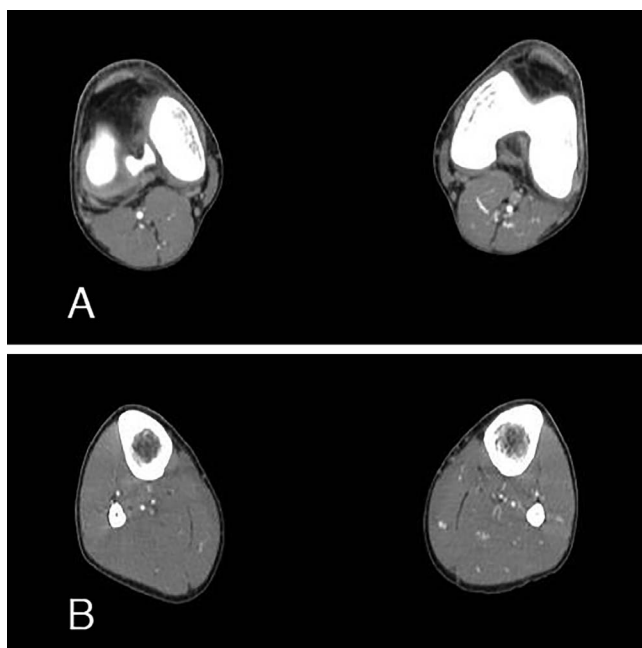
Axial computed tomography angiography images show (A) arterial anatomy at the popliteal that originates from the anomalous posterior circulation (the posterior persistent sciatic artery) bilaterally and (B) arterial anatomy at the distal popliteal with normal 3-vessel runoff into the anterior tibial, posterior tibial, and peroneal arteries.
